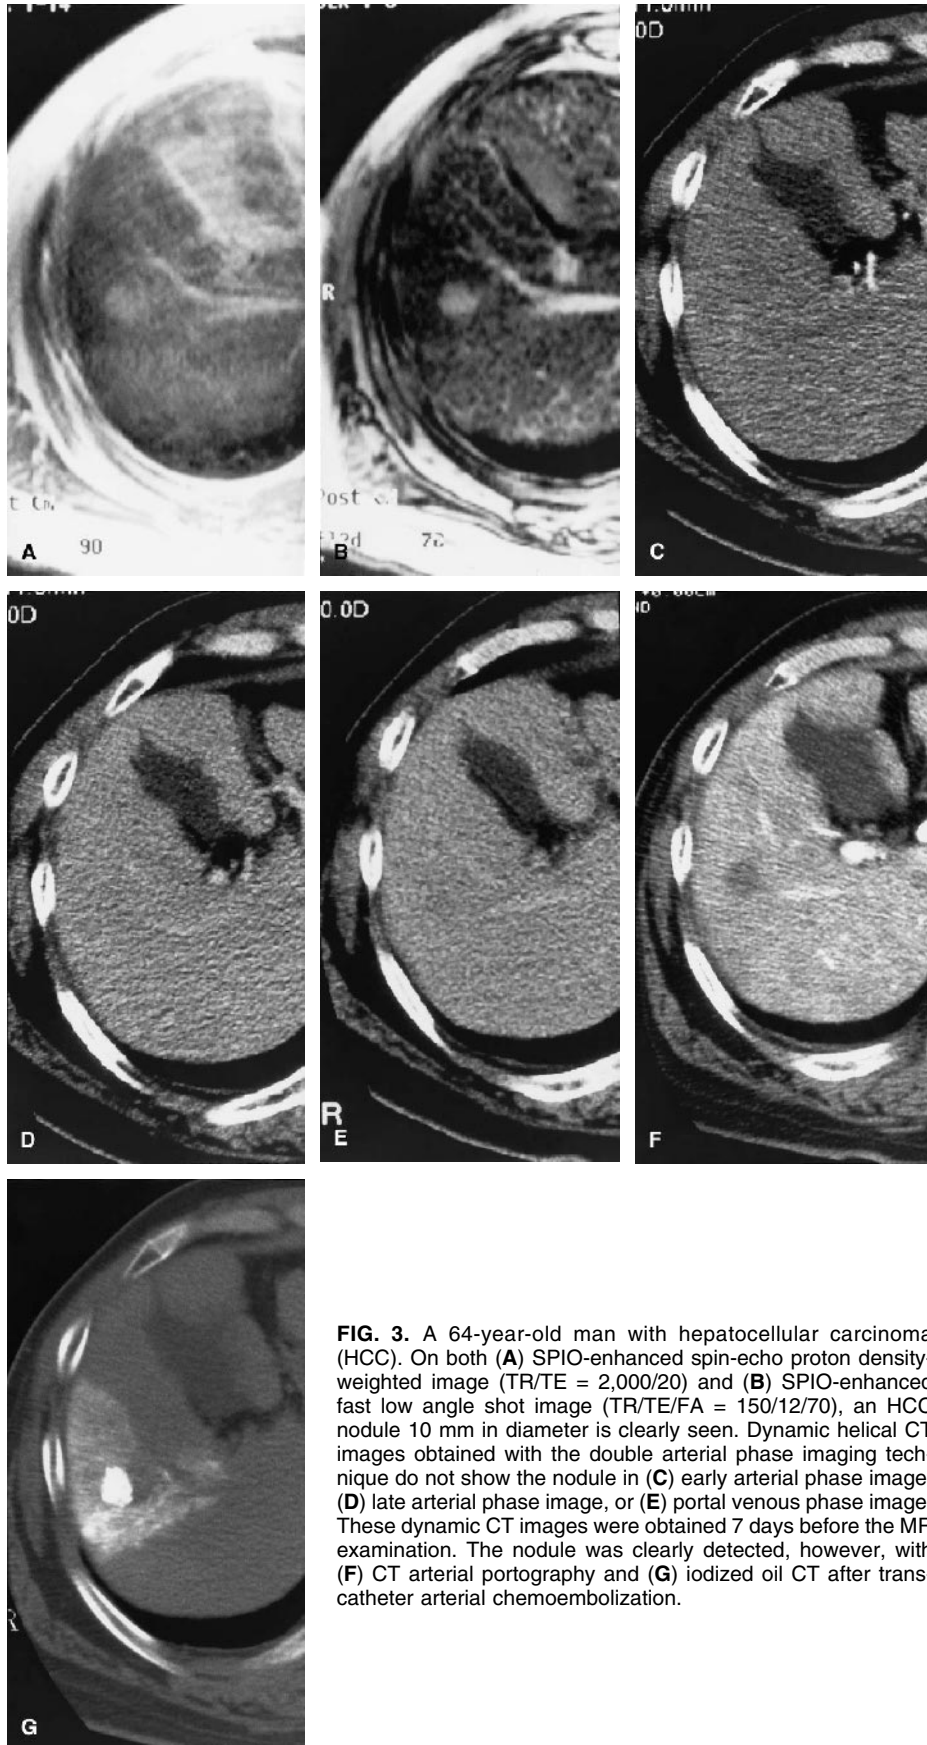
A 64-year-old man with hepatocellular carcinoma (HCC). On both (A) SPIO-enhanced spin-echo proton density-weighted image (TR/TE = 2,000/20) and (B) SPIO-enhanced fast low angle shot image (TR/TE/FA = 150/12/70), an HCC nodule 10 mm in diameter is clearly seen. Dynamic helical CT images obtained with the double arterial phase imaging technique do not show the nodule in (C) early arterial phase image, (D) late arterial phase image, or (E) portal venous phase image. These dynamic CT images were obtained 7 days before the MR examination. The nodule was clearly detected, however, with (F) CT arterial portography and (G) iodized oil CT after transcatheter arterial chemoembolization.
